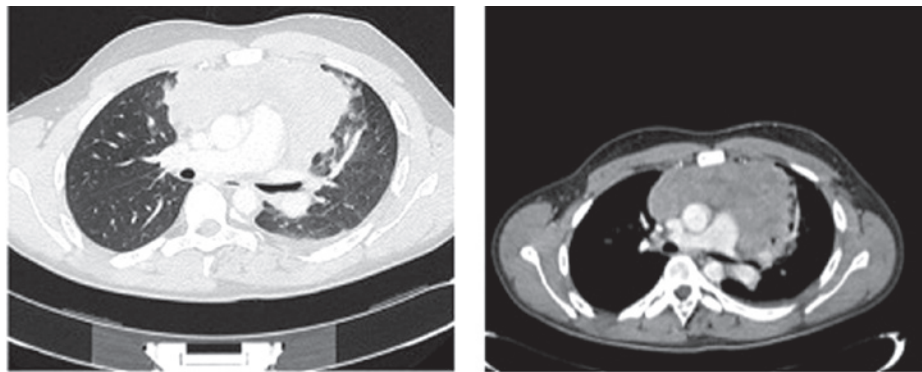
Axial computed tomography without a contrast agent in the mediastinal window (right) and with a contrast agent in the parenchymal window (left) shows mixed lymphoma appearing as a voluminous solid mass with irregular margins, and internal necrosis in the left anterior superior mediastinum; compression of the left lung apex, jugular vein and the left common vein is observed.
